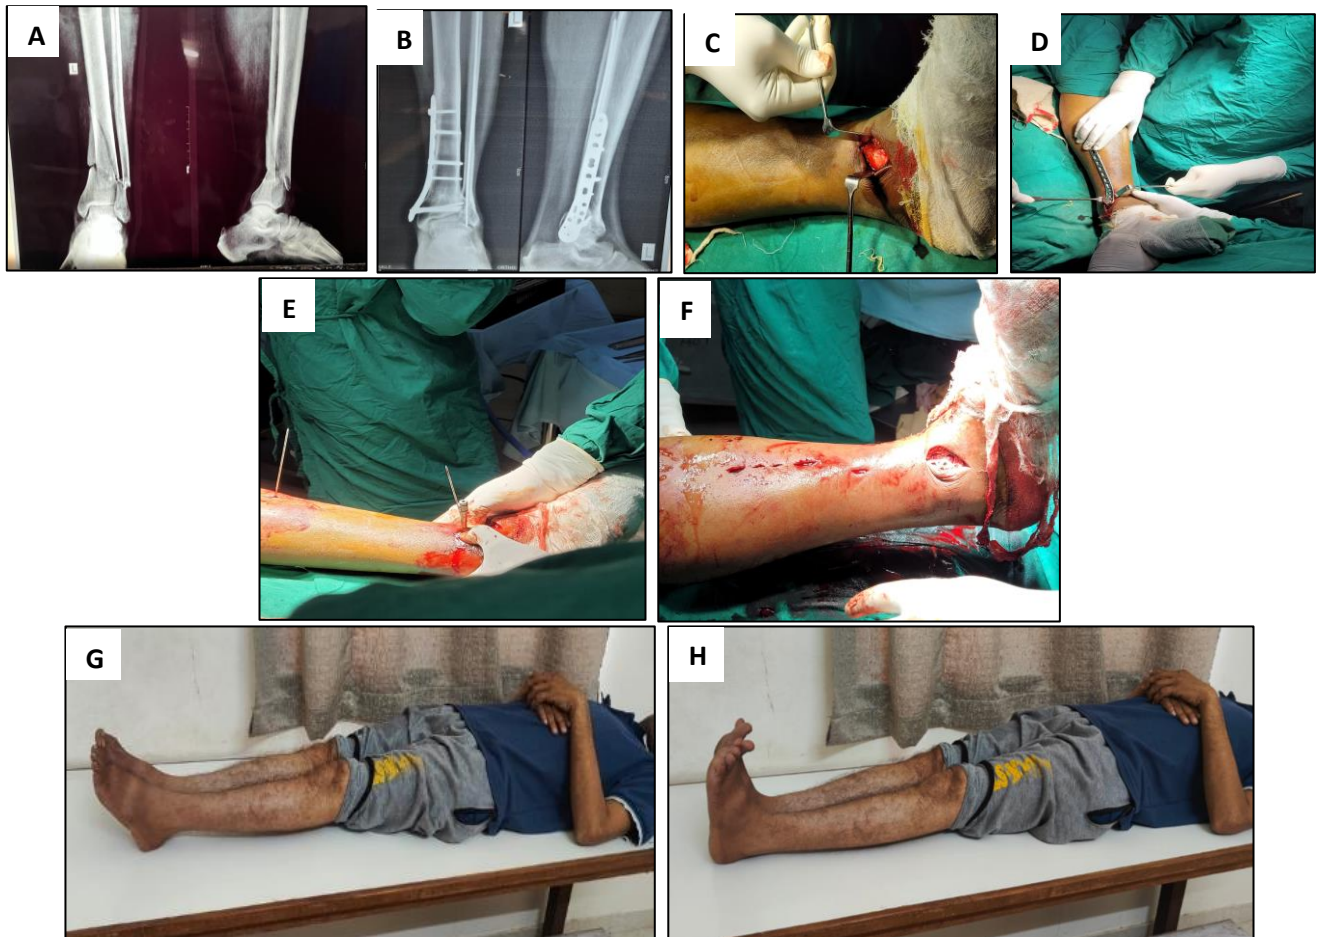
Open reduction and internal fixation for plating using MIPPO technique. A) Pre op X-ray; B) post op X-ray; C) skin incision; D) assessing the plate length; E) distal screw locking with sleeve; F) stab incisions for proximal locking; (G and H) patient showing full ROM at 6 months follow up after intramedullary nailing.
